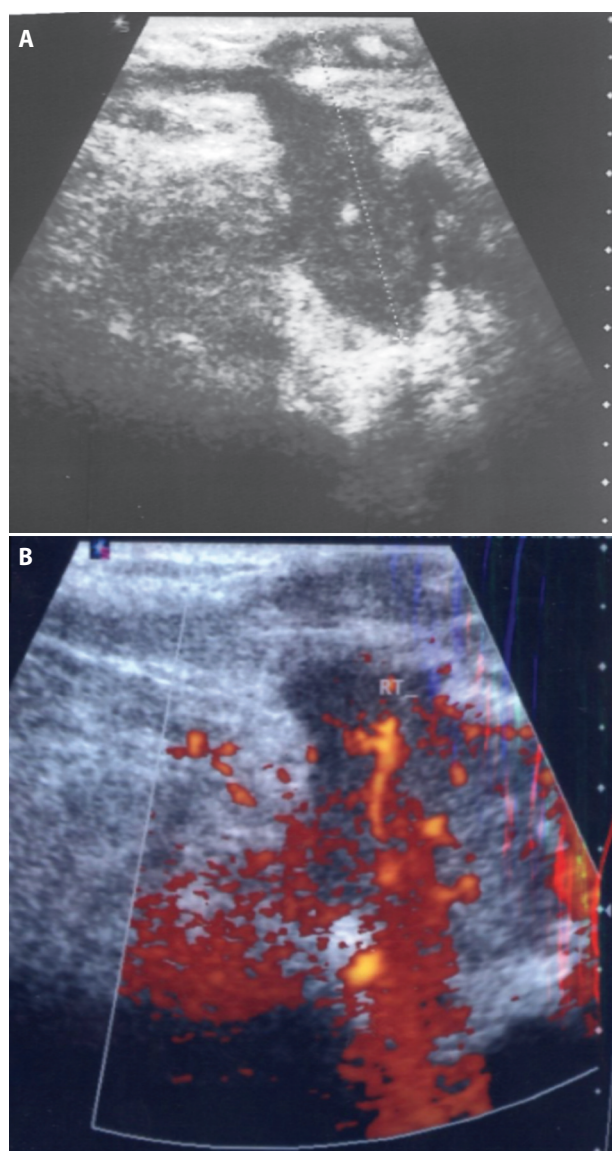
B. Neck ultrasound revealing multiple swollen lymph nodes, maintaining their shape and vascularization, in a phase of acute inflammation, accompanying a spindle-like sub-sounded inflammatory region, with increased anarchic internal vascularization, ending in a tube-like outgrowth beneath the skin like fistula.
